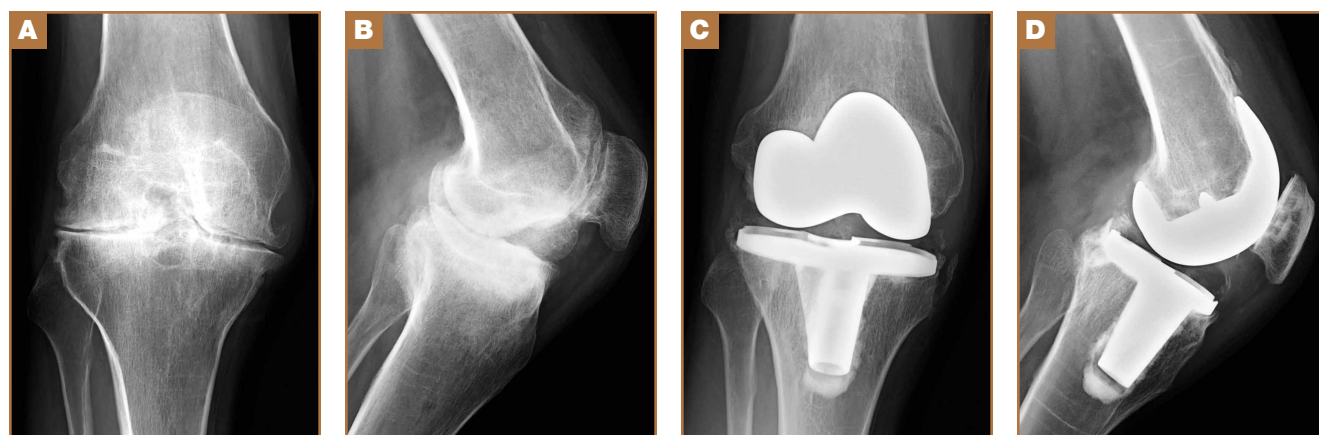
Severe hemophilic arthropathy in 39-year-old hemophilic patient after successful total knee arthroplasty (NexGen, Zimmer) with patellar resurfacing. (A) Preoperative anteroposterior (AP) radiograph, (B) preoperative lateral radiograph, (C) AP radiograph of implanted prosthesis, and (D) lateral radiograph of implanted prosthesis.
